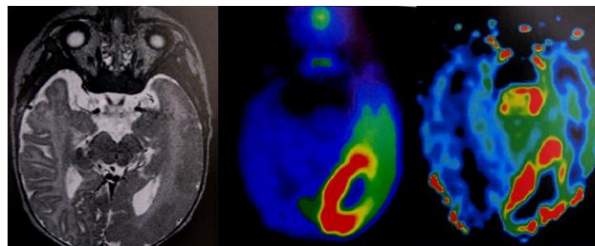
PET scan utilizes radiotracers mainly glucose (FDG) to suggest metabolic areas with glucose uptakes. The minimal thickness of slices is 6 mm. Regions with high metabolite concentrations will be apparent in the given color scale. PET scans and more recently ASL (Arterial Spin Labeling) perfusion scans are used to differentiate true and pseudoprogression in glial brain tumor imaging assessment.
